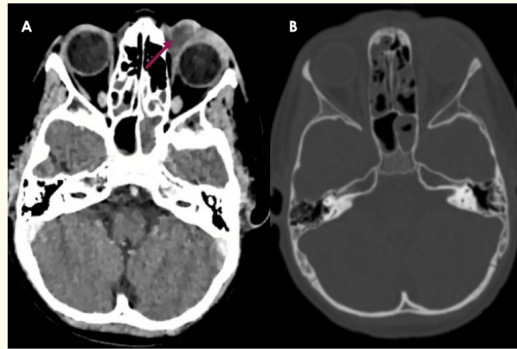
Orbito-cerebral enhanced CT scan with axial sections on parenchymal (A) and bone (B) windows showing a hyper enhancing heterogeneous mass in the left extraconal compartment without mass effect on adjacent structures or invasion of the surrounding bony orbit.
